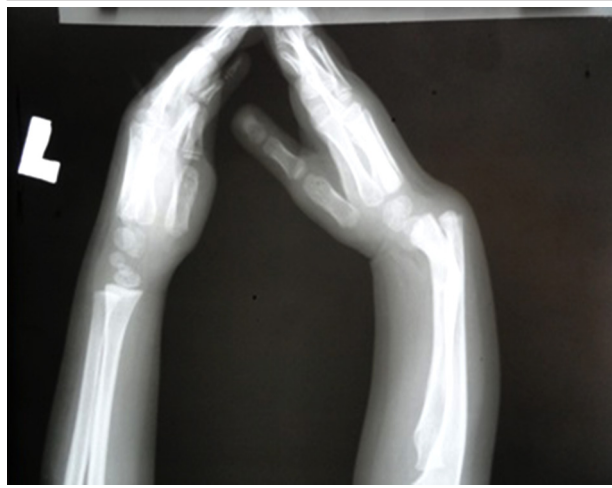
Radiography of Both Wrist, Case No. 2
